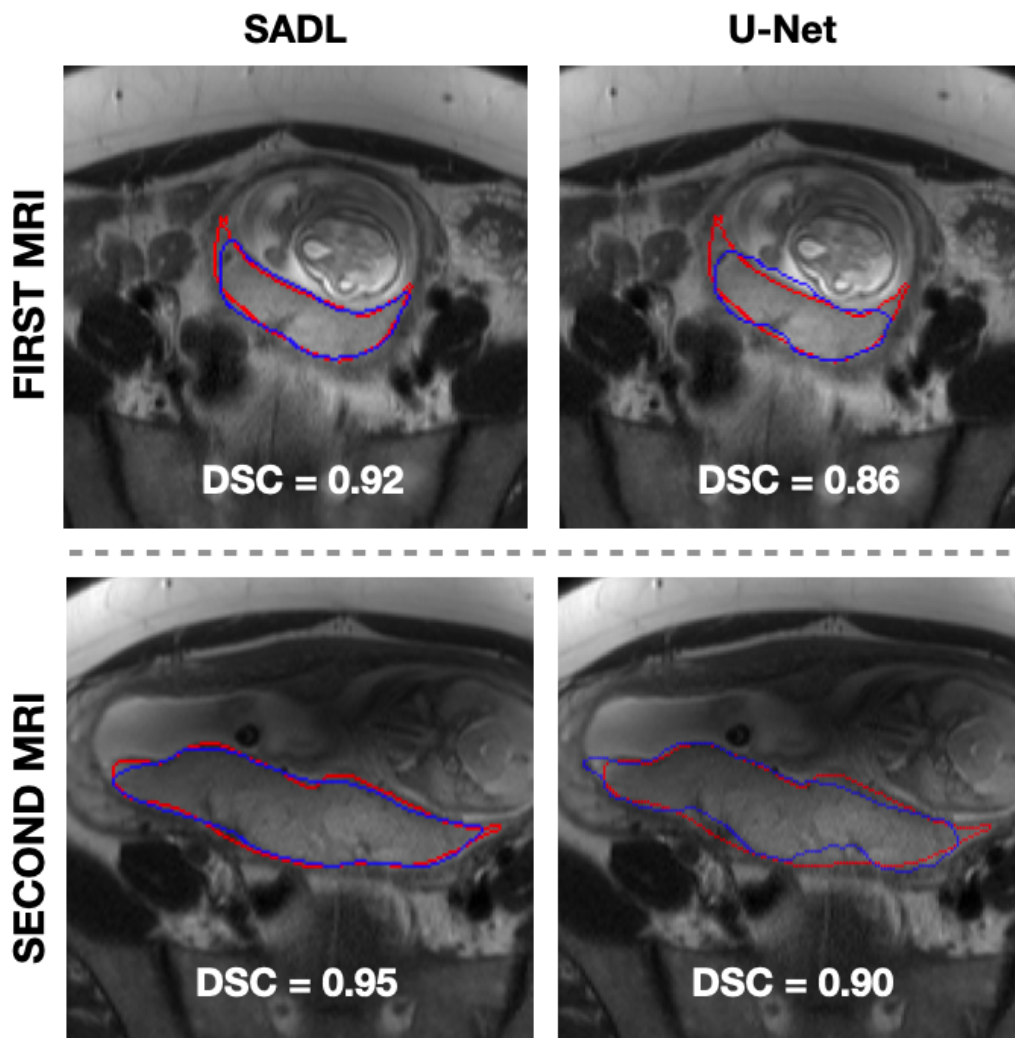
Representative example of automated segmentation by SADL and U-Net (blue lines) compared to the manual segmentation (red lines) at the first MRI (*GA* = 15 weeks and 1 day) and the second MRI (*GA* = 19 weeks and 4 days). DSCs are shown below.
